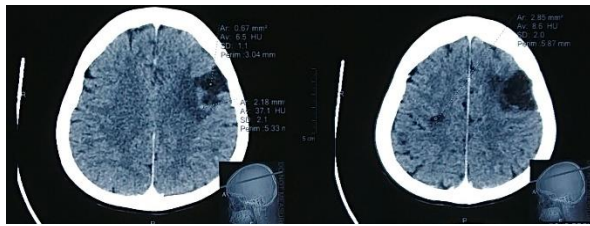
An evaluation CT with contrast was taken, no apparent enhancing lesion was found, vasogenic edema and midline shift was reduced.
